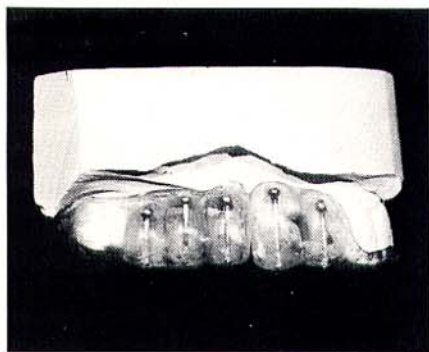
Buccal view of a "radiographic correction stent". Although 5 mm diameter metal balls can be used as "radiopaque markers", in this case orthodontic ball clasps were utilized. The markers should be positioned mesiodistally to correspond to the pre-selected implant locations. See Fig. 6 for the panoramic view with this appliance seated "in the mouth".
